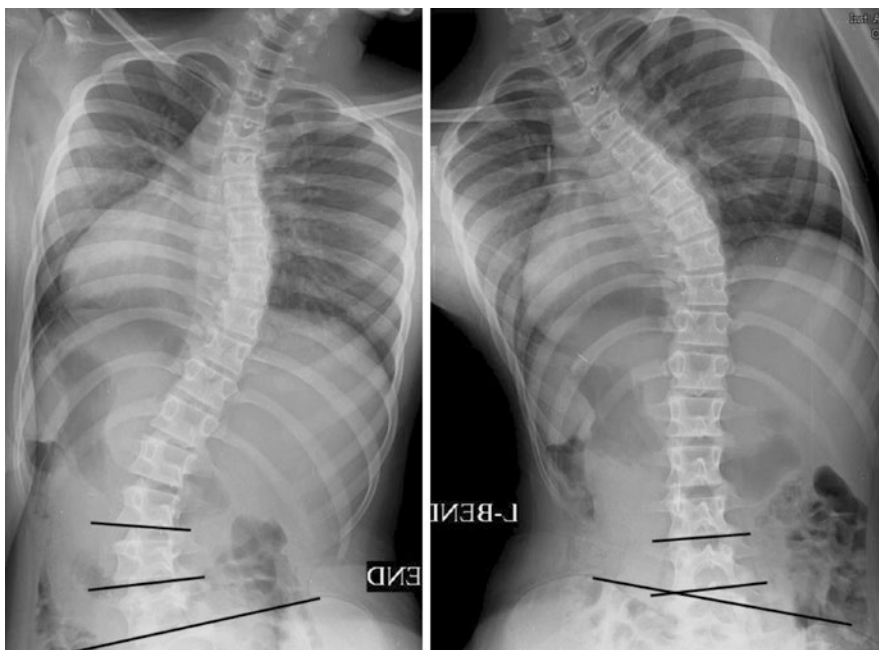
The lower endplate of the LIV should be parallel to the pelvis on one of the two bending X-rays
